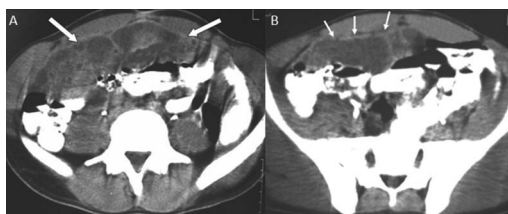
Axial contrast-enhanced CT images showing large amount of loculated viscous fluid (arrows; A) and enhanced diffuse peritoneal thickening (arrows; B). Posteriorly displaced small bowel loops could be seen.
